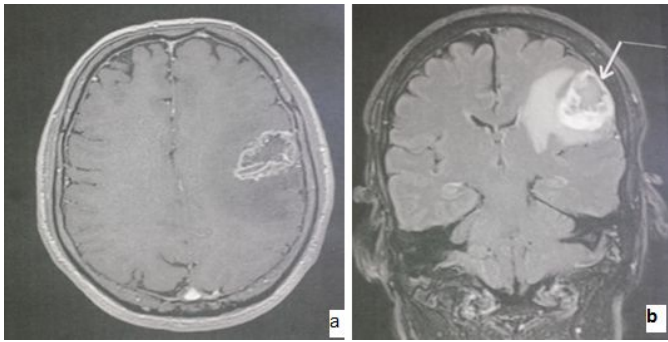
Left parietal brain metastasis with dual component cystic and fleshy with peritumoral edema on T1 MRI a- axial T1 MRI b- coronal T2 MRI.
